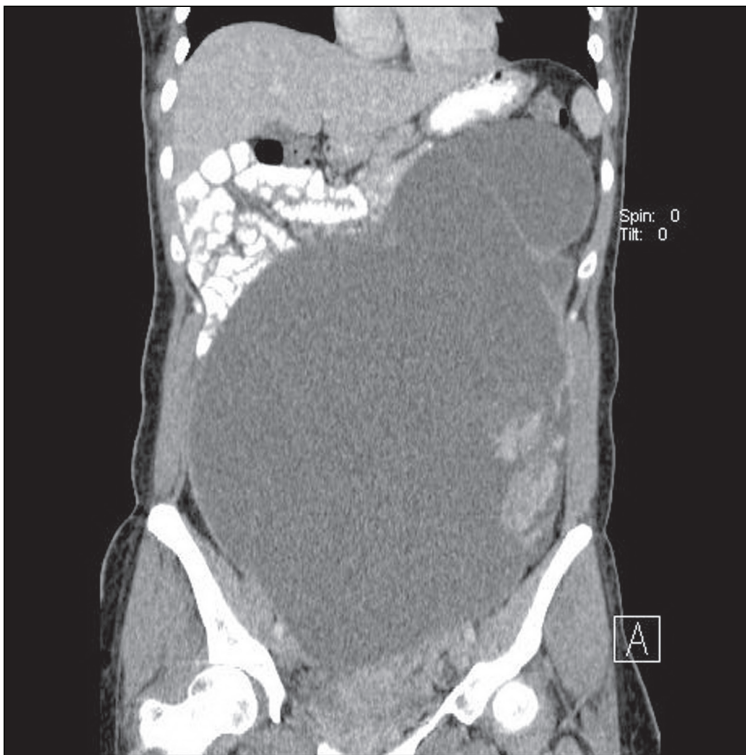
The abdominal CT scan. One huge cystic tumor in homogeneous internal attenuation, at least two foci of solid parts, around 4.5 cm attach to left lateral wall of the tumor.
